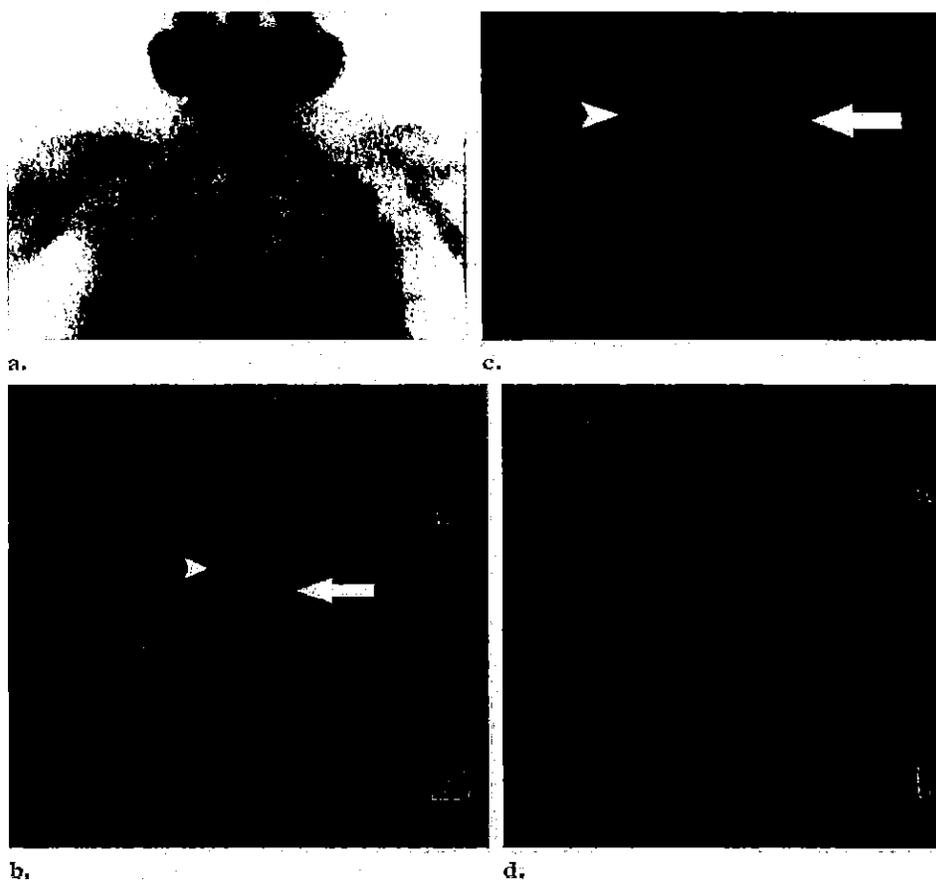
Both true-positive and false-positive findings in a woman with hyperparathyroidism. (a) Subtraction (^{99m}Tc sestamibi and iodine 123) planar image shows two foci of uptake. (b–d) Coronal (b), axial (c), and sagittal (d) SPECT/CT images show that the large left-sided focus corresponds to thyroid tissue (arrow in b and c), whereas the right-sided activity (arrowhead in b and c) is external to the thyroid. At surgery, the right-sided abnormality was a parathyroid adenoma, whereas the left-sided abnormality was a thyroid adenoma.
